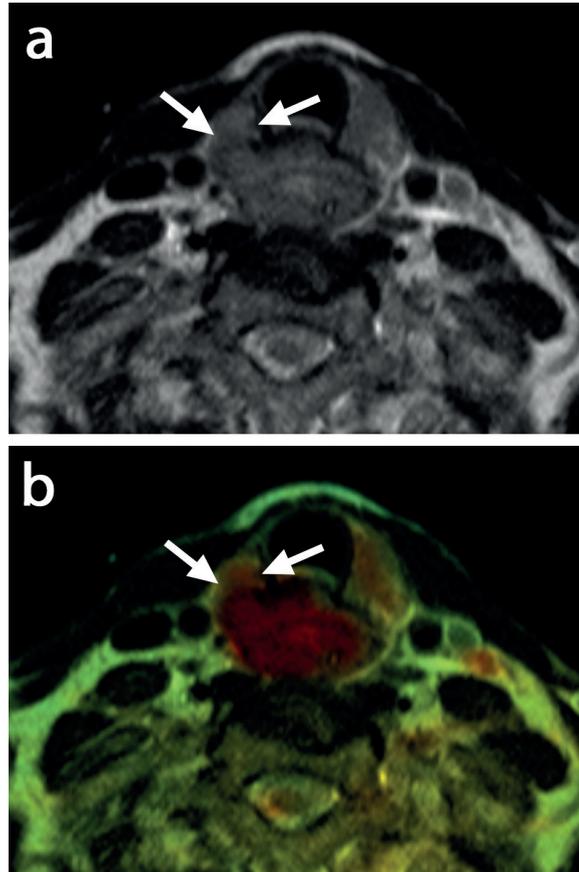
A 59 year-old man diagnosed with a proximal stenotic esophageal squamous cell carcinoma. (a) Transverse high-resolution T2-weighted MRI at the level of the neck demonstrated invasion of the esophageal tumor into the right thyroid gland (*arrows*). (b) The corresponding fusion T2-weighted/DW image showed diffusion restriction within the tumor (*color*) including the suspected site of thyroïdal ingrowth (*arrows*). External ultrasonography of the neck confirmed the clinical T4b disease.
